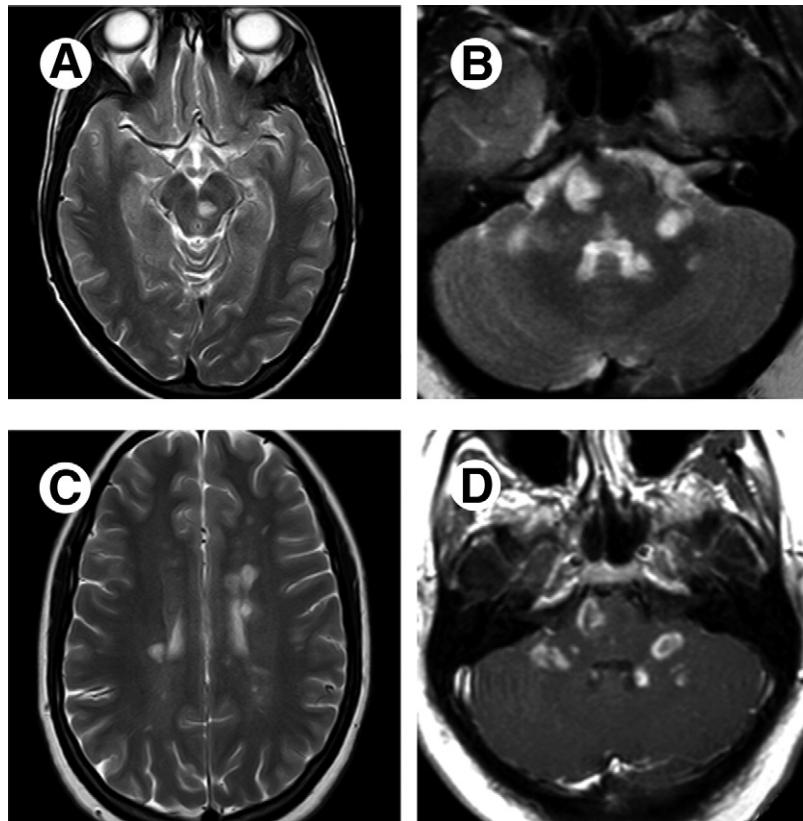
MS. Axial TSE T2-weighted image (A) shows increased focal signal in the left mesencephalic red nucleus. Axial TSE-T2 (B) shows multiple hyperintense periventricular focal lesions on the anterior surface of the pons and in both middle cerebellar peduncles. Axial TSE T2-weighted image (C) reveals multiple hyperintense focal lesions perpendicular to the long axis of the lateral ventricles. Axial gadolinium-enhanced 3D FFE-T1-weighted image (D) shows nodular, complete and incomplete ringlike enhancement patterns.
